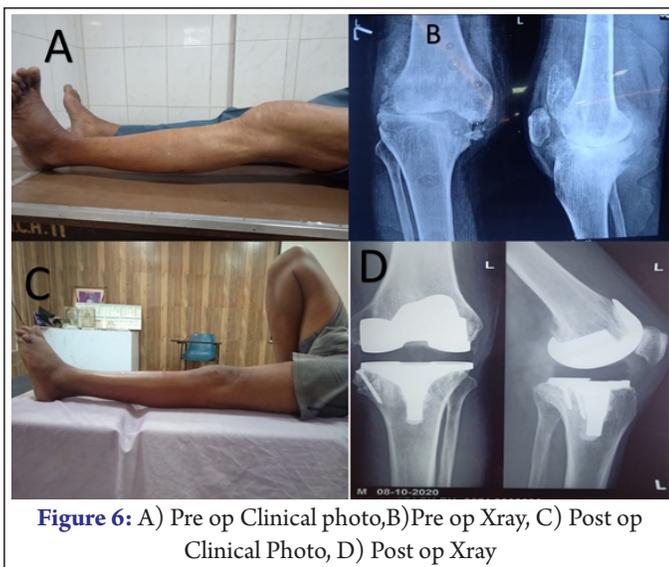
A) Pre op Clinical photo, B) Pre op Xray, C) Post op Clinical Photo, D) Post op Xray
